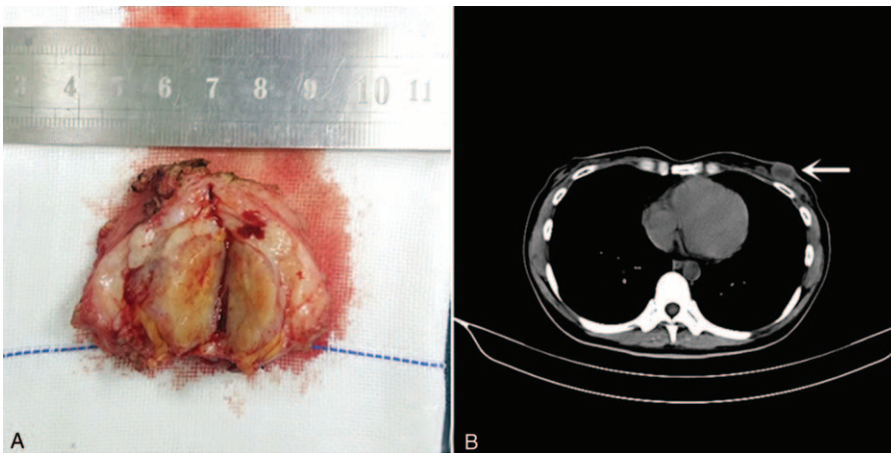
A. Gross examination showed the breast lesion with the diameter of 2.5 cm in the outer lower quadrant of the left breast. B. Computed tomography examination showed a soft 22-mm × 17-mm lesion of tissue-like density with a central patchy low-density area in the lower quadrant of the left breast with a well-defined boundary.
